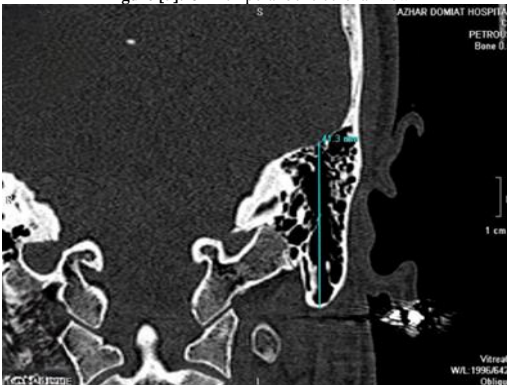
CT Temporal bone coronal view
